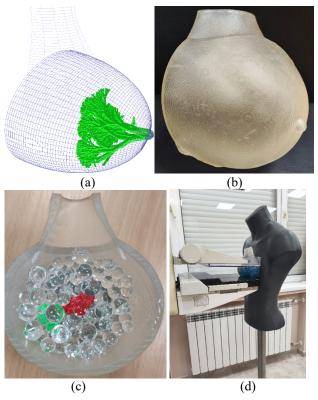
Educational breast model: (a) computational breast model, (b) printed breast model, (c) printed model with tumour, glandular tree and adipose structures, (d) mounted model on the mannequin at a mammography training system (no X-ray tube)
